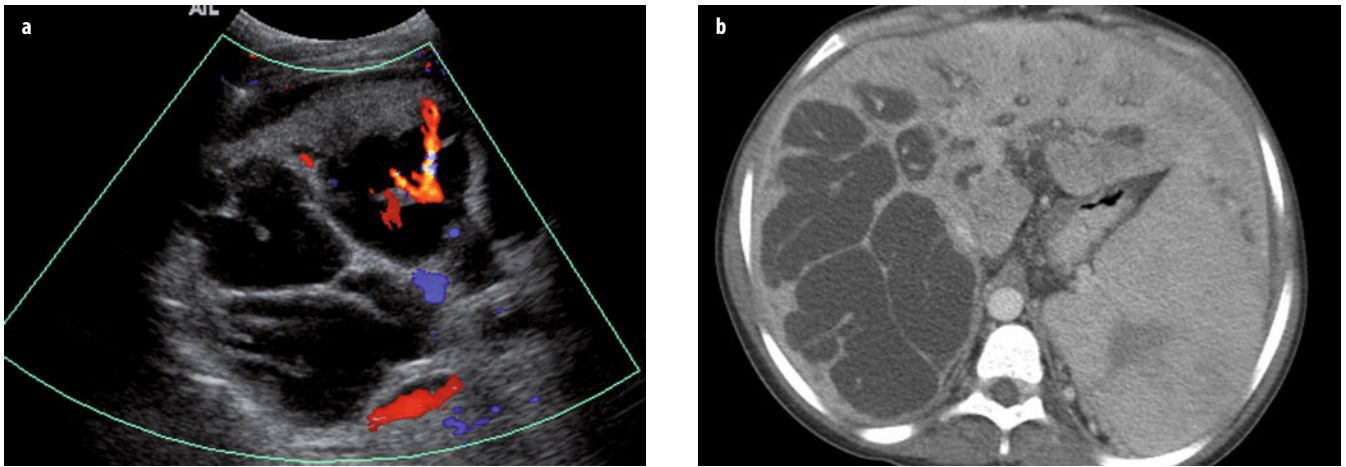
a, b. Caroli disease. a Transverse ultrasound (US) image of the liver shows large cystic structures that contain a central dot and small portal venous radicles. b Contrast-enhanced computed tomography (CT) using intravenously administered contrast medium in the same patient shows marked dilatation of the intrahepatic bile ducts in the right lobe, with the central dot sign. The liver is cirrhotic; the spleen is enlarged and contains a focal area of infarction
